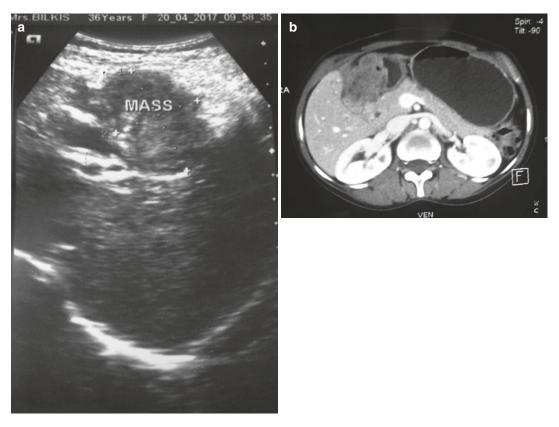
"Missed" gall bladder cancer (a) US (b) CT shows a soft tissue mass in the gall bladder fossa infiltrating the prepyloric antrum
